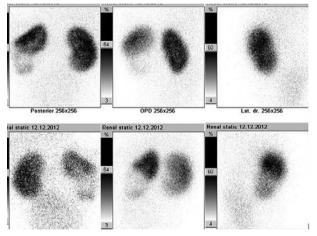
Case 5: 99m technetium dimercaptosuccinic acid (DMSA) scintigraphy: significant decrease in radionuclide uptake in the left lower moiety.
